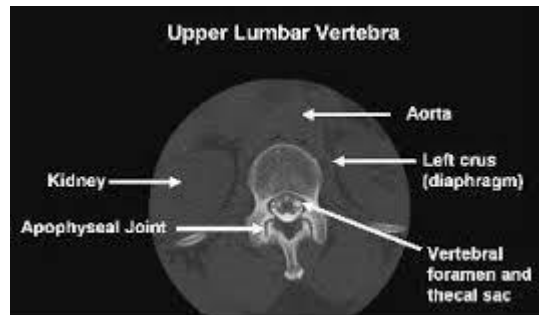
shows axial CT scan of upper lumbar spine (Website ;WWW.Radiology Info.com)
